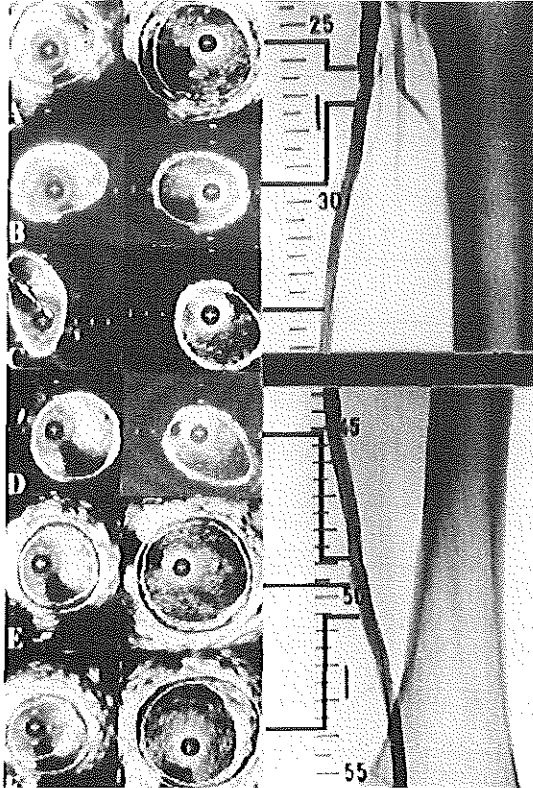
Matched intravascular ultrasound cross-sections of a femoropopliteal artery after endograft placement (left panel) and at follow-up (middle panel) with the corresponding angiogram (right panel). Note absence of plaque inside the endograft. A distinct dilatation seen at the anastomotic segments (A, E, F) is absent in the endograft (B-proximal edge; C-inside endograft; and D-distal edge). Angiography shows a dilatation, but the change is less prominent.
